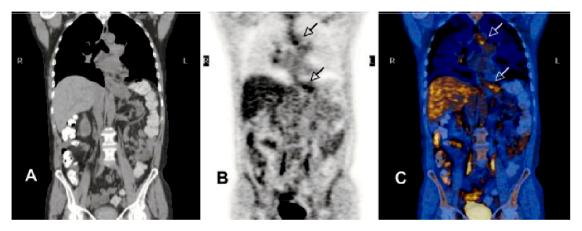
Integrated PET/CT of a patient showing NPA = 2 in the primary and mediastinum (arrows). (A) CT scan; (B) PET scan; (C) integrated image.
